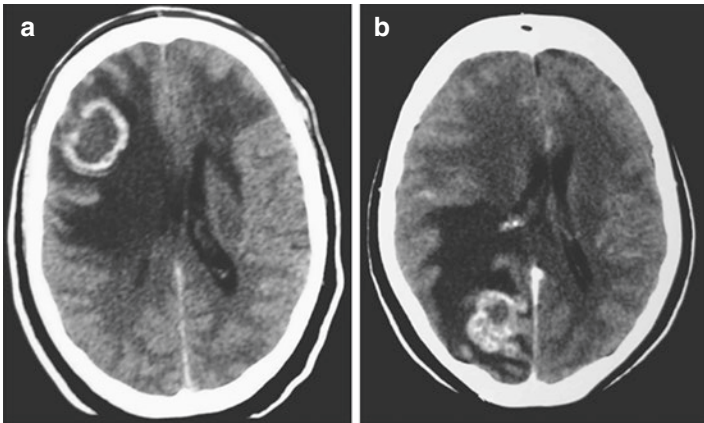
(a, b) Are post-contrast CT scans showing two obvious lesions. This picture is intended to reinforce the not infrequent similarity between tumors and infective lesions. Image A is a metastatic lung carcinoma and image B is a biopsy proven tuberculosis (TB) granuloma
